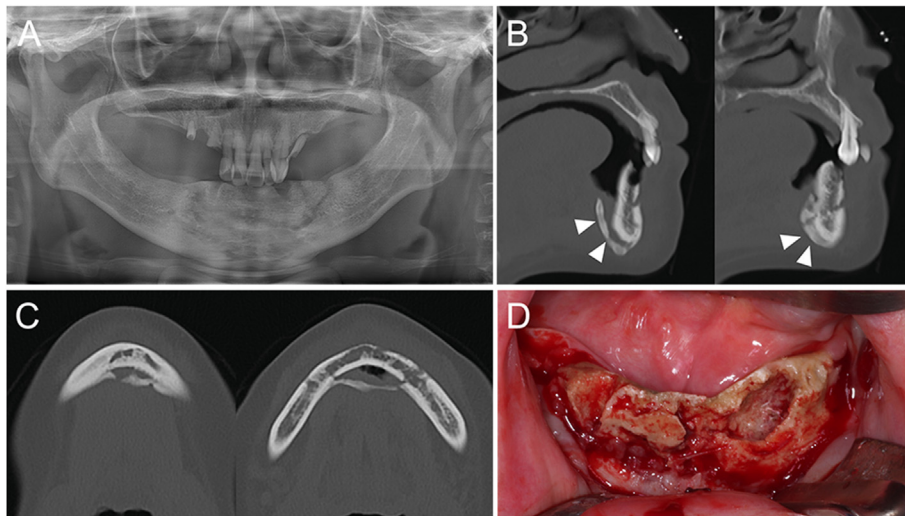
Preoperative radiographs and clinical photographs of Case 4. (A) Preoperative panoramic view. (B, C) Preoperative computed tomography images showing severe bone destruction extending to the inferior mandibular border, with pronounced periosteal reaction along the cortical bone, leading to consolidation (arrowhead). (D) Intraoperative clinical photograph.
